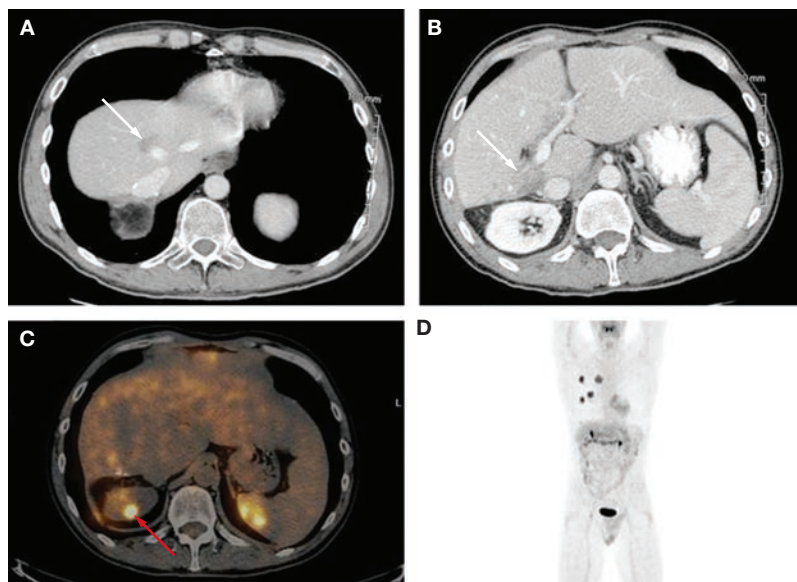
CT, PET-CT and whole-body PET images obtained 6 weeks after yttrium-90 microsphere embolization in a patient with diffuse large B-cell lymphoma. (A) CT image showing near complete resolution of the hypodense lesion in the dome of the liver (arrow). (B) CT image showing near complete resolution of the hypodense lesion in the left lobe of the liver (arrow). (C) PET-CT fusion image showing complete resolution of the liver tumors. The red arrow indicates normal ^{18}F -FDG uptake in the right kidney. (D) Whole-body PET image of the patient showing resolution of all sites of abnormal uptake within the liver, but four new ^{18}F -FDG-positive lesions in the right lung.
